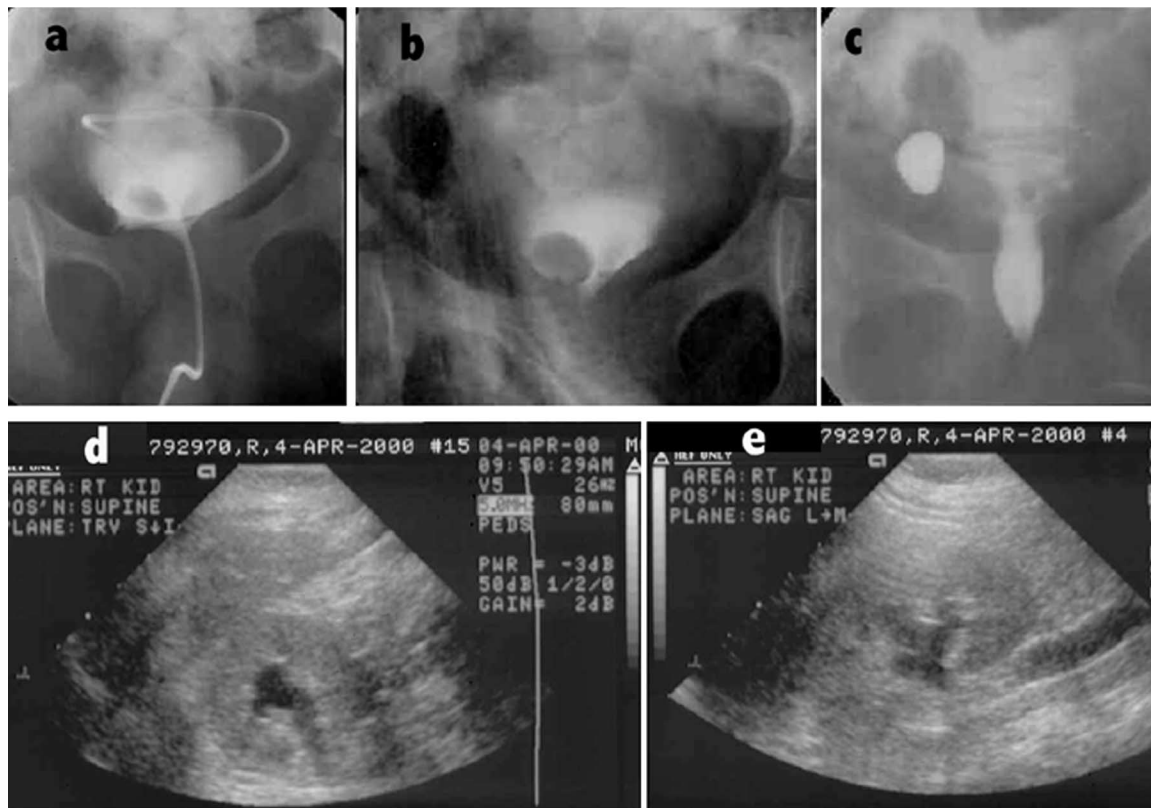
Radiographic findings in case #1. Retrograde cystography showing a large right-sided and a smaller left-sided ureterocele seen as filling defects on initial filling phase (a), and voiding phase of the study (b). Post void film in (c) shows a bladder diverticulum on the right side. Renal ultrasound findings of the right kidney in the same patient showing a hyperechoic kidney with poor corticomedullary differentiation and minimal hydronephrosis in transverse (d) and sagittal (e) views.
